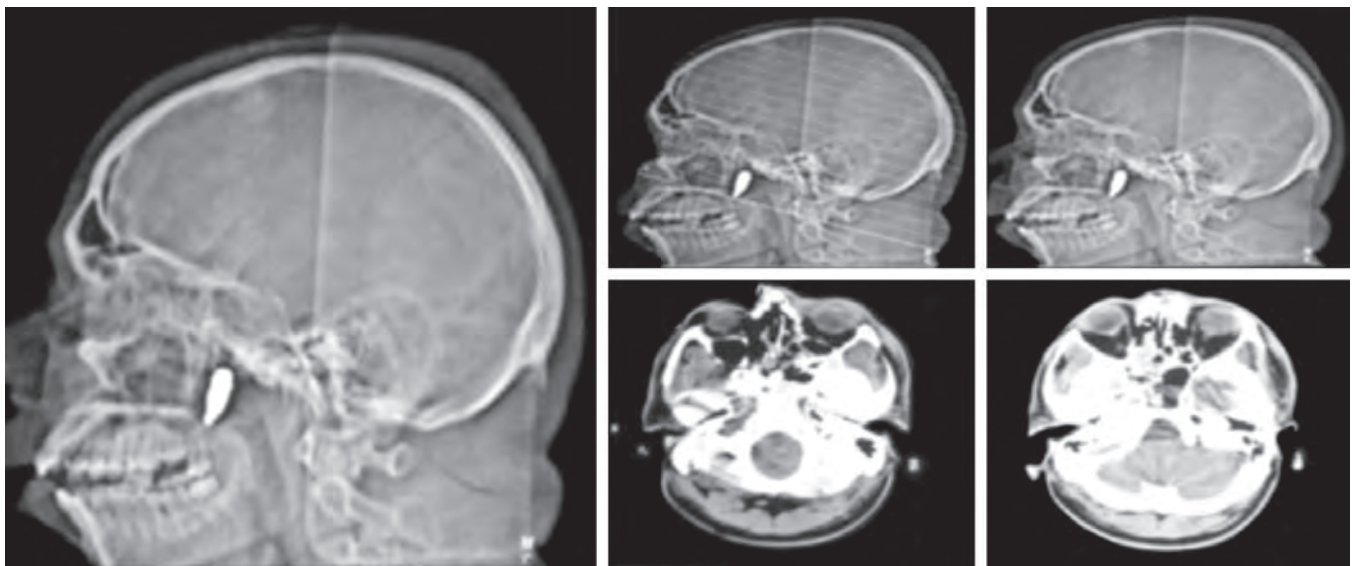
CT scan of the head in a case of bullet injury in the right eye with optic nerve injury
